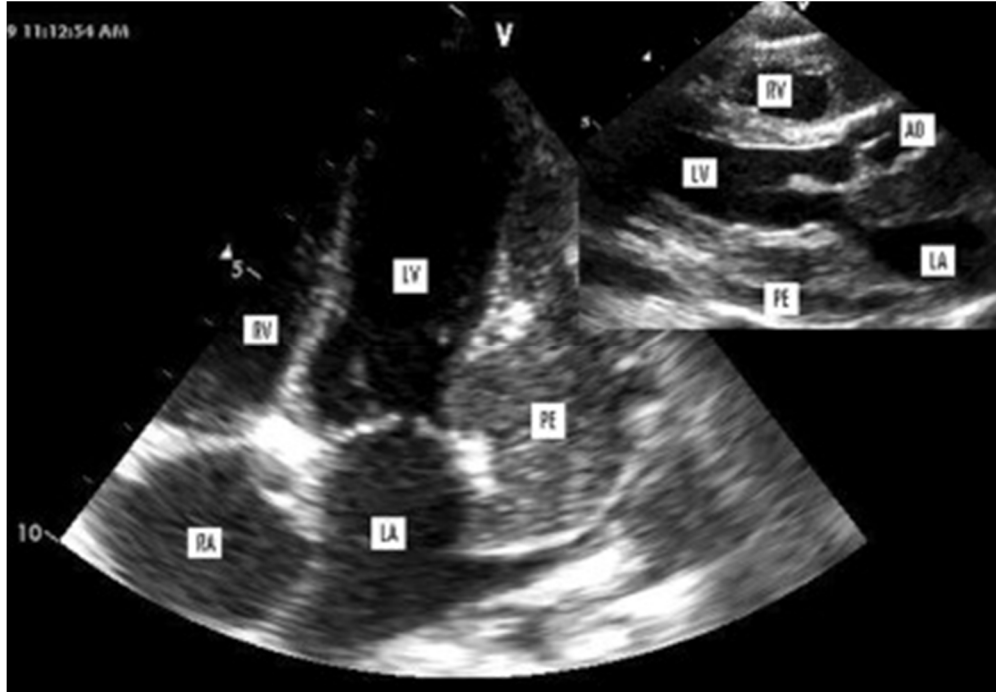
Apical four-chamber view and parasternal long-axis view echocardiogram (inset) demonstrating the organized loculated pericardial effusion. (AO = aorta; LA = left atrium; LV = left ventricle; PE = loculated organized pericardial effusion; RA = right atrium; RV = right ventricle.)
